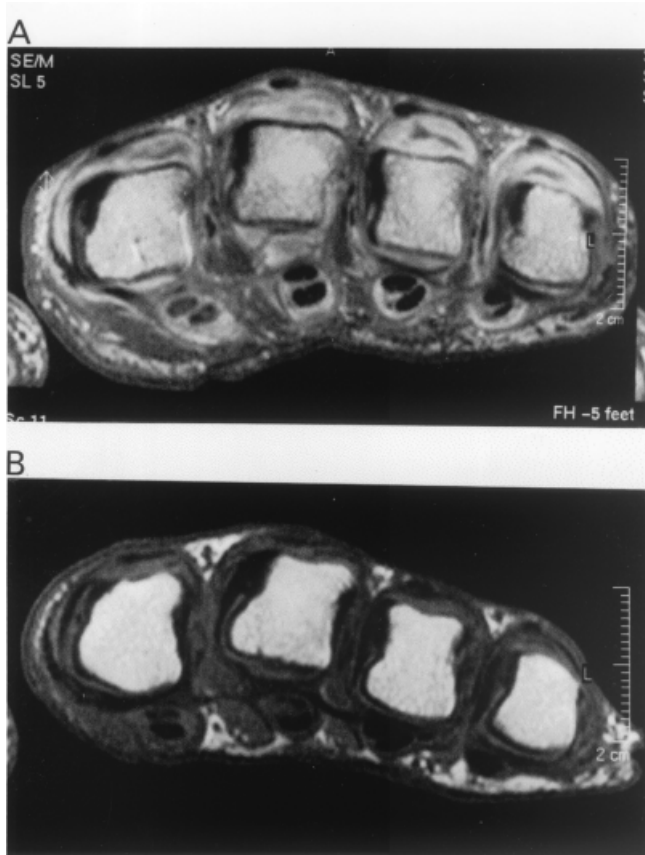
Magnetic resonance imaging of the metacarpophalangeal joints. Axial T1-weighted spin-echo post-gadolinium views of the same patient (responder) at baseline (A) and week 14 (B), showing dramatic reduction in enhancing synovium (synovitis) and tenosynovitis.
